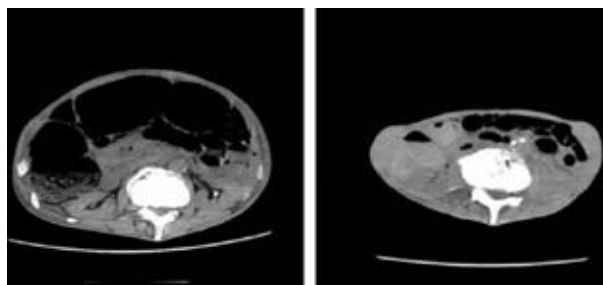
Abdominal CT findings of the gastrointestinal pseudo-obstruction after surgery (left) The abdominal CT findings of the megacolon on postoperative day 2. (right) The abdominal CT findings after treatment with intravenous administration of phentolamine.
